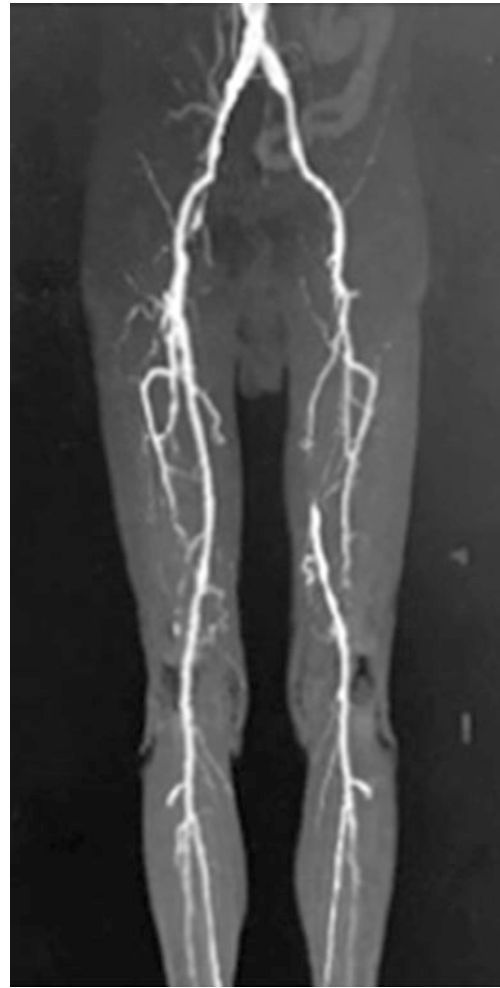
Preoperative CTA
